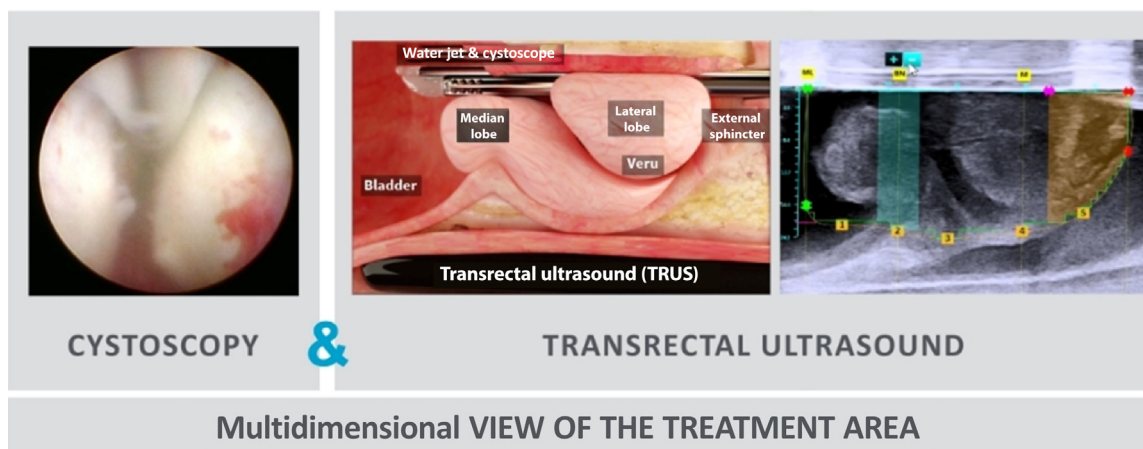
Intraoperative images of the Aquablation technique. The upper figure shows the cystoscopic view and initial ultrasound-guided contouring of the glands. The lower figure shows the same cystoscopic and ultrasound images demonstrating the results of water jet resection. Veru = verumontanum.
